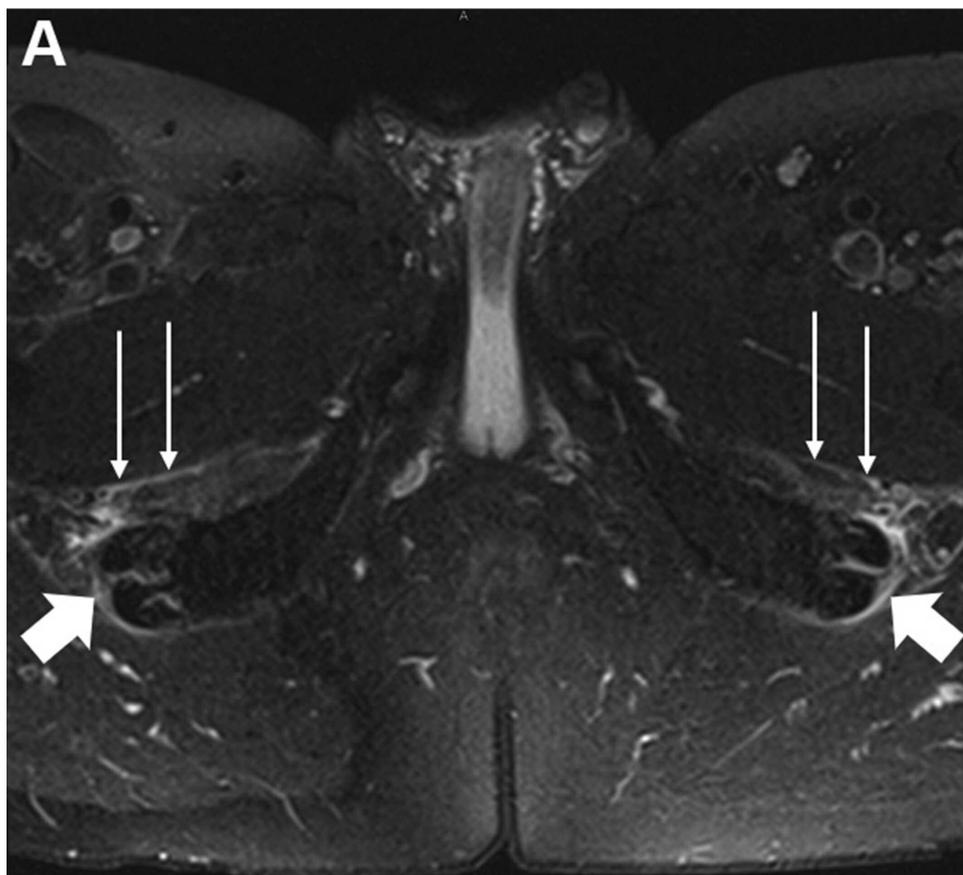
Musculotendinous inflammation in polymyalgia rheumatica (PMR). A. T2-weighted FS MRI reveals the close anatomical relationship between previously documented proximal hamstring peritendonitis (thick arrows) and newly recognized localized myofascial inflammation of the obturator externus (thin arrows) in a patient with PMR. B. A depiction of musculotendinous pathology in PMR arising from the connective tissues of the tendons and muscles (peritendineum and perimysium) to involve adjacent structures including the joint capsule and bursa. Used with permission.
